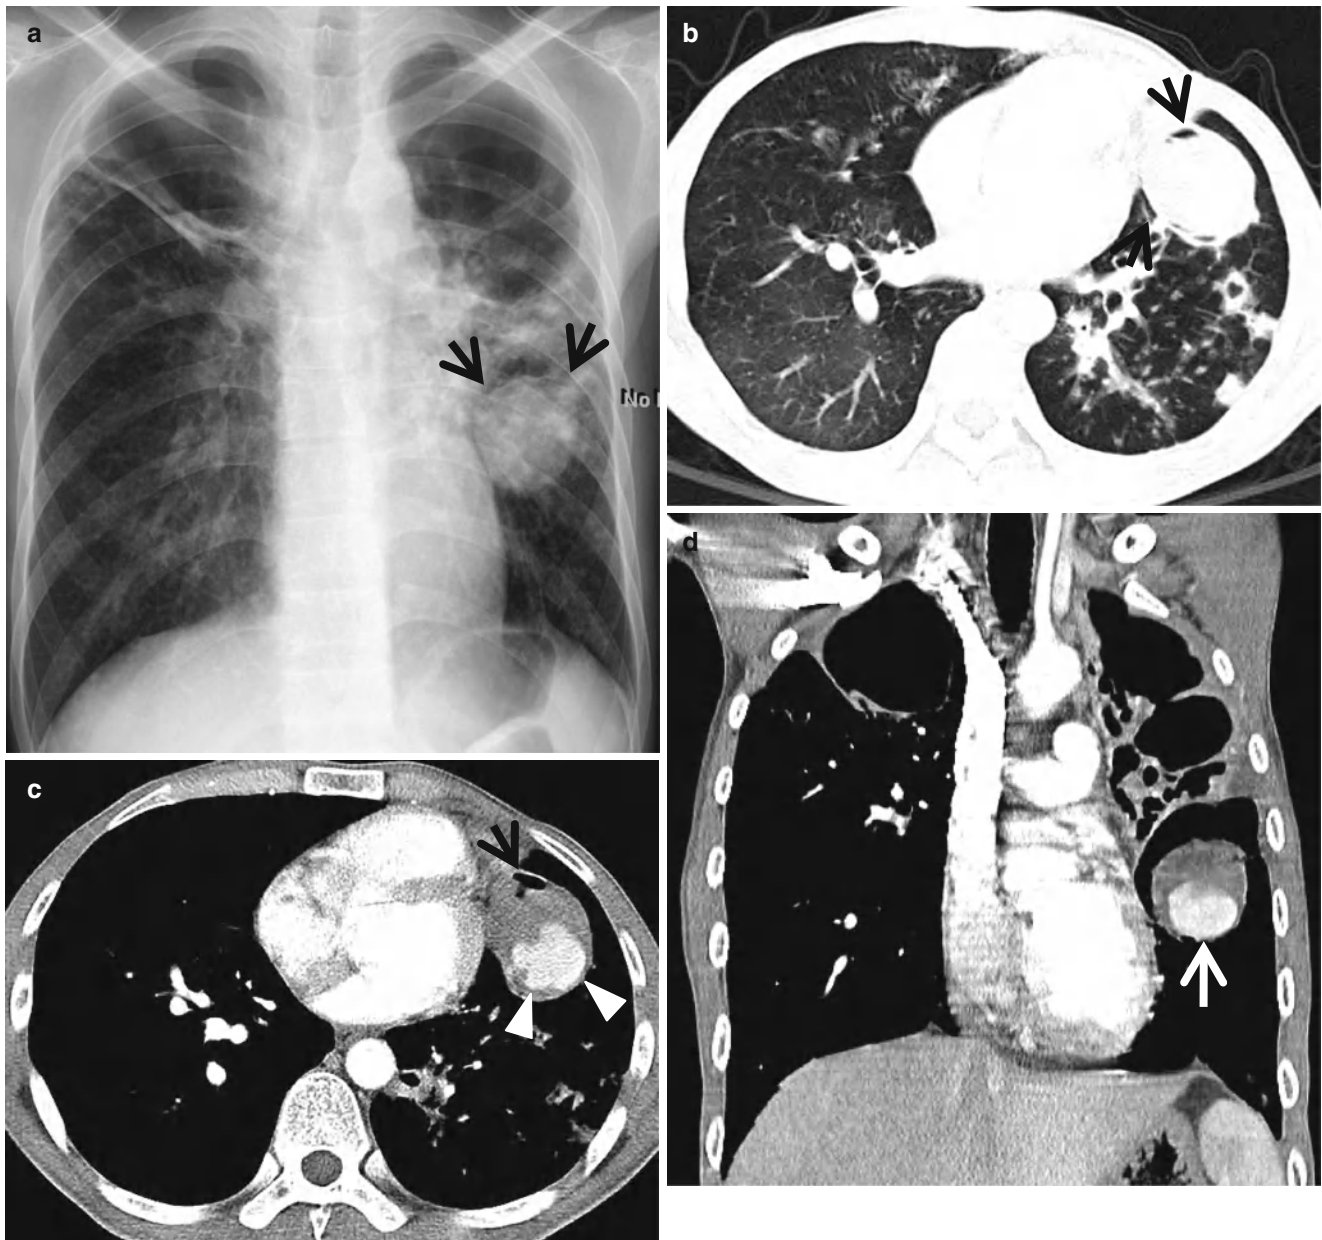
Air-crescent sign in a Rasmussen's aneurysm in a 34-year-old man. (a) Chest radiograph shows destructive tuberculous lesions in the bilateral upper lung zones in which bullae are also seen. Also note a mass showing air-crescent sign (arrows). (b) Lung window image of thin-section (2.5-mm section thickness) CT scan obtained at level of right inferior pulmonary vein shows a soft tissue mass depicting air-crescent sign (arrows) in lingular division of left upper lobe. Also note
